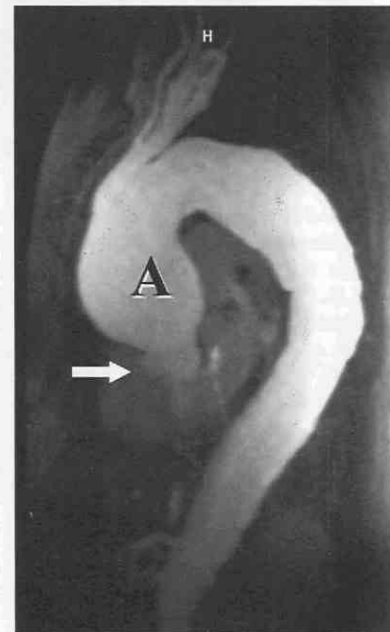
Sagittal oblique gadolinium-enhanced MR image shows aneurysmal dilatation of the ascending aorta (A) with sparing of the sinuses of Valsalva (arrow).
